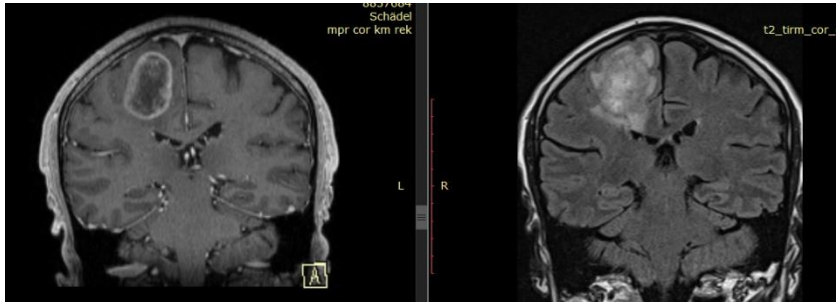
MRI. Lung cancer unique brain metastasis (Personal collection of dr. Vicențiu Săceleanu)
